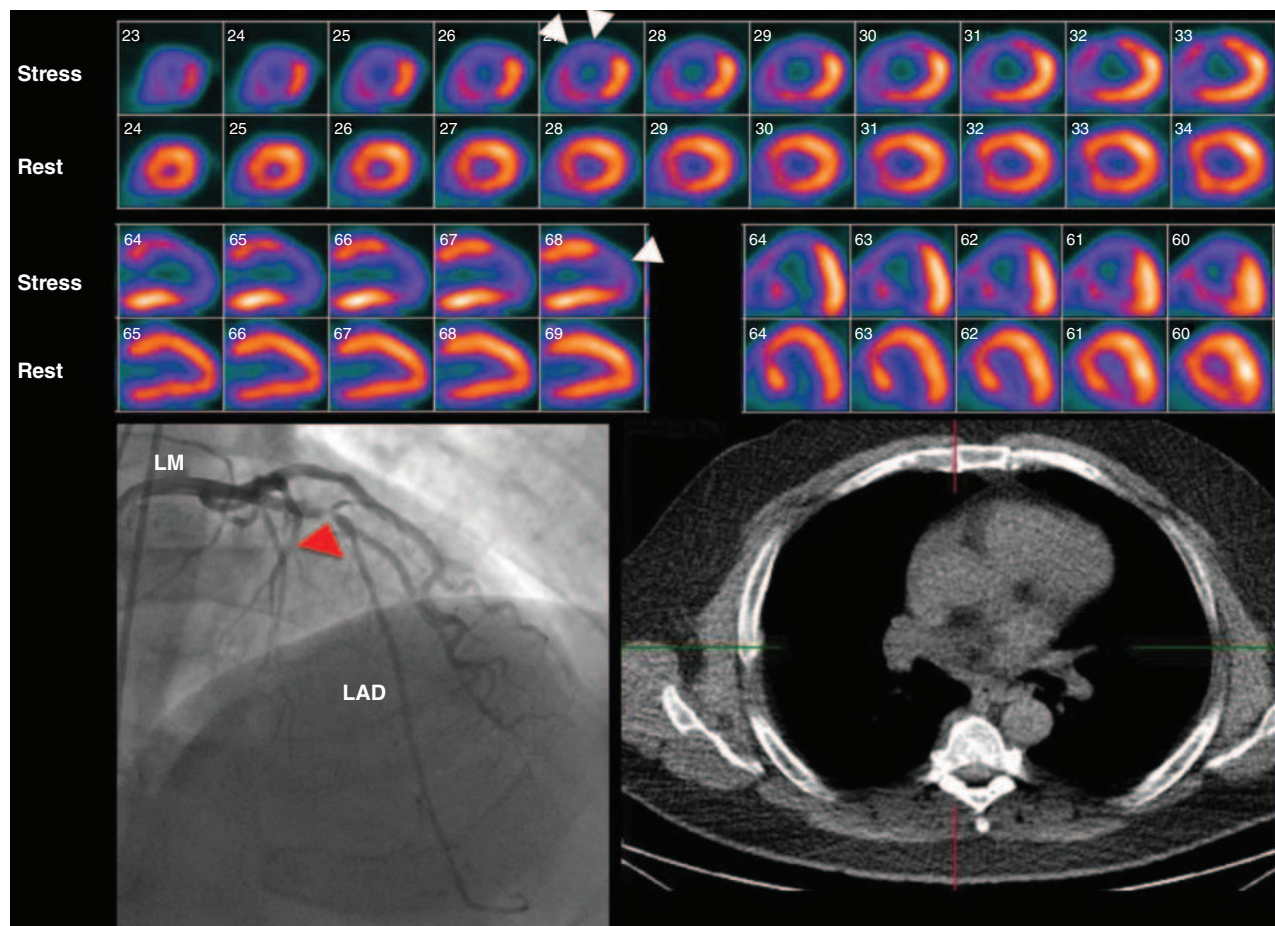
Stress and rest rubidium-82 myocardial perfusion positron emission tomography images (*top*), noncontrast gated computed tomography images (*lower right*), and selected coronary angiographic images obtained on a 59-year-old male patient with atypical angina. Despite the absence of significant coronary calcifications (Agatston calcium score = 0), the perfusion images demonstrated a dense and reversible perfusion defect involving the anterior and anteroseptal walls (*arrows*), reflecting significant obstructive disease in the left anterior descending coronary artery (LAD), confirmed on angiography. LM, left main artery.
